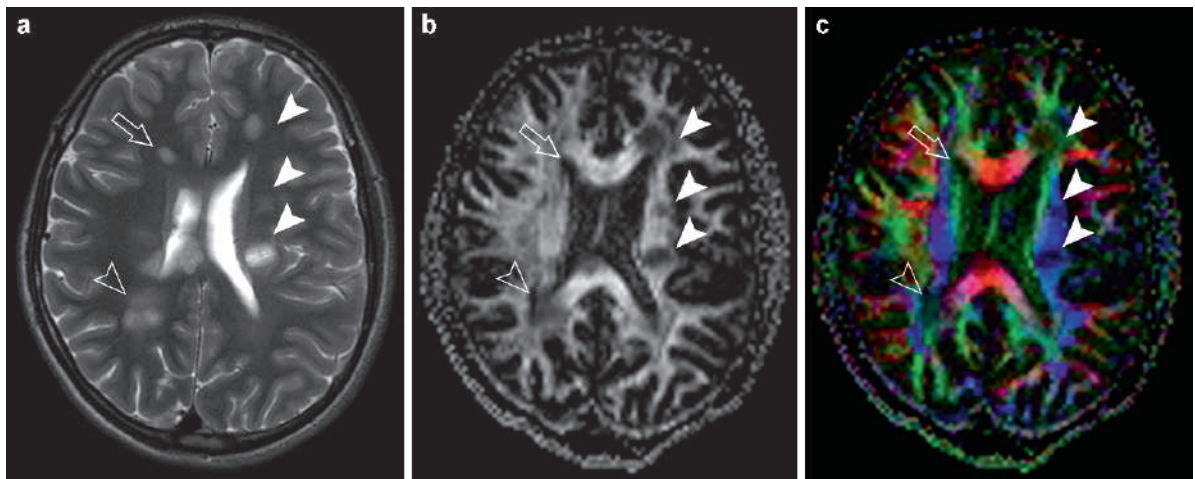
Axial T2W brain MRI (a), diffusion-encoded FA map (b), and color-coded FA map (c) of a 16-year-old patient with MS. By comparing (a) with (b) and (c), the MS plaques can be assessed according to the white matter tract affected: the left
